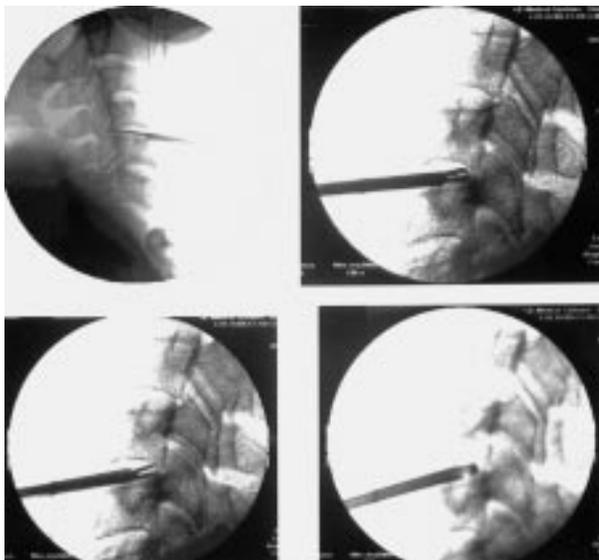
X-rays of curette (upper left), cutter (upper right), grasper (lower left), and discectome (lower right) in disc space.
